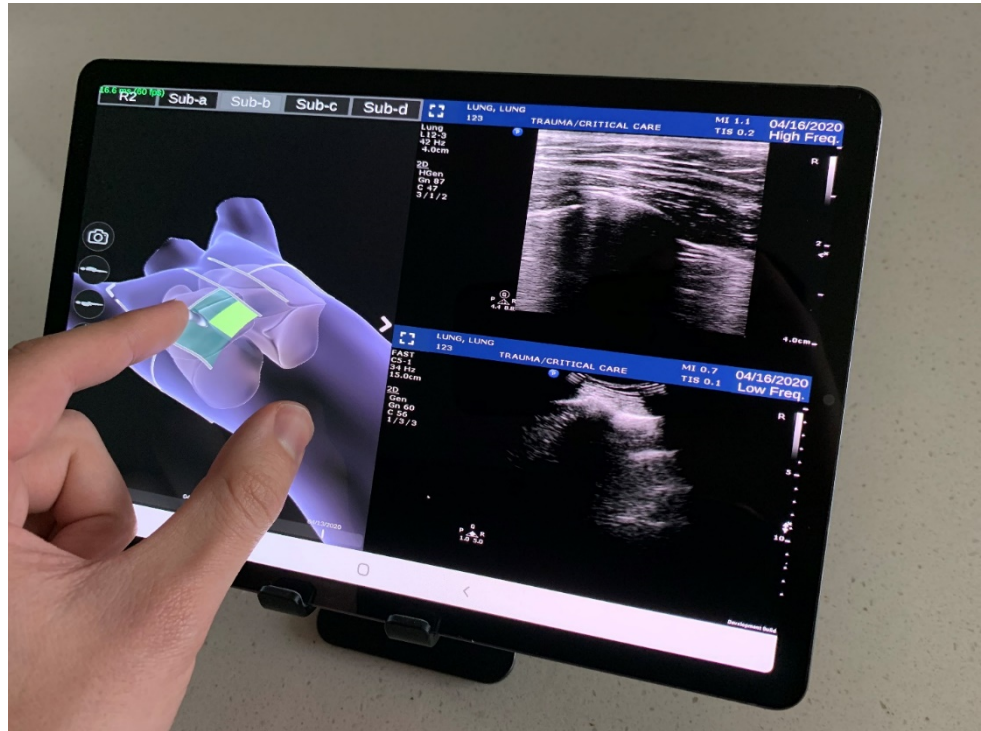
MBRC's ultrasound database and visualization app under development.
